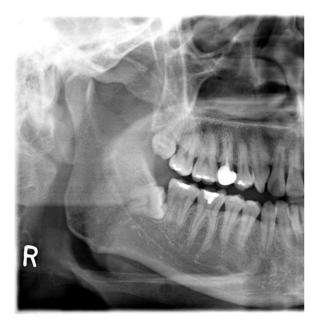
Panoramic radiograph of Case No.2 showing the upright maxillary third molar and the horizontally impacted opposing mandibular third molar.
